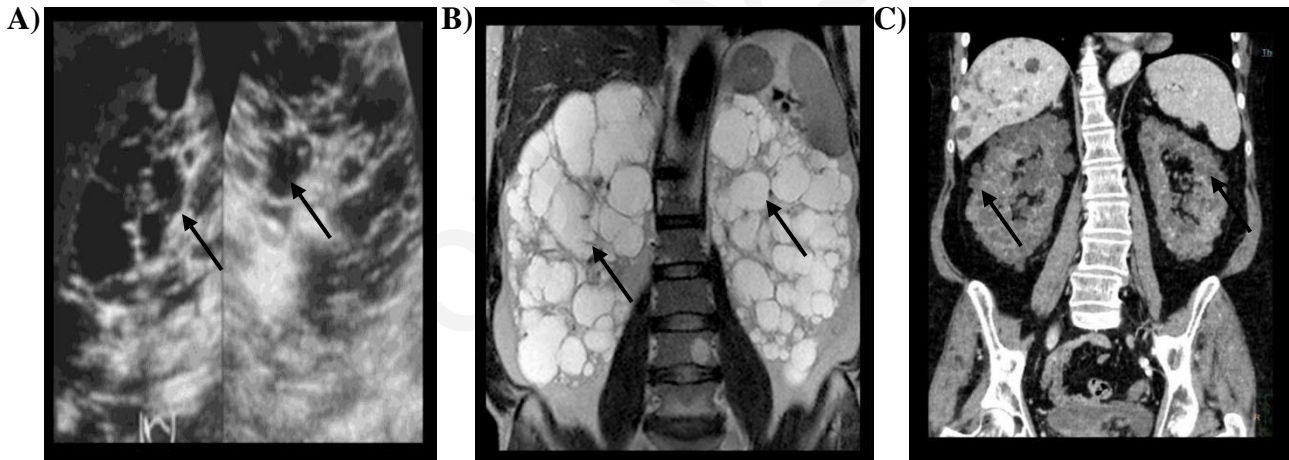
Diagnostic imaging techniques. A) Ultrasound- cysts be displayed as irregular sphere shape with black colour, B) MRI- cysts be displayed as irregular sphere shape with white colour, C) CT scan- cysts be displayed as irregular sphere shape with (Gradzik et al., 2016).
